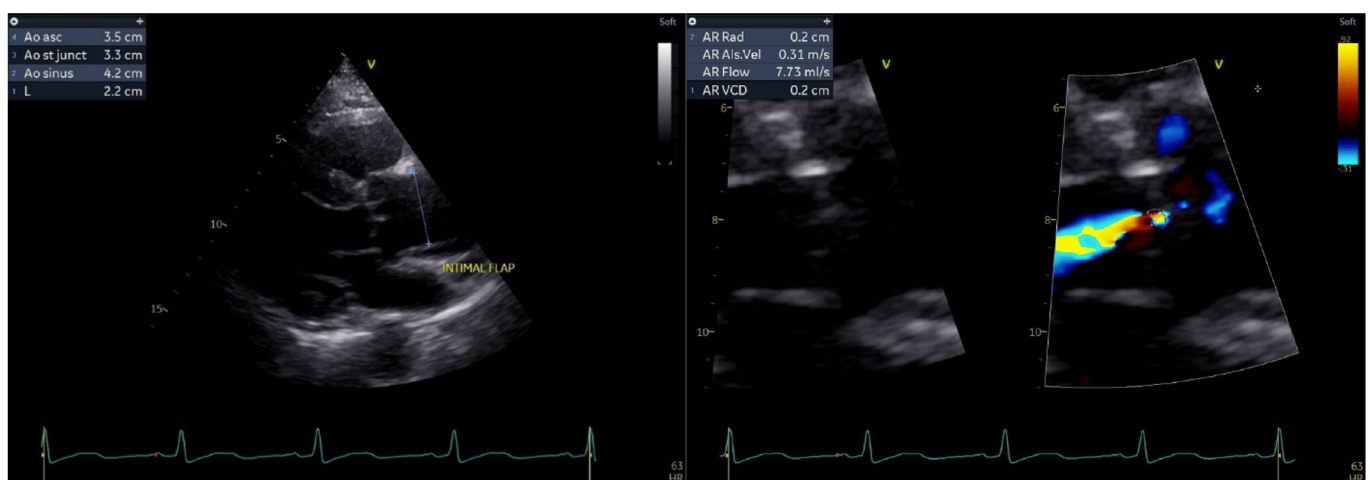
Echocardiography was performed, and an intimal tear was visible in the root of the aorta distal to the valve. There was also seen acute aortic regurgitation in color Doppler.
